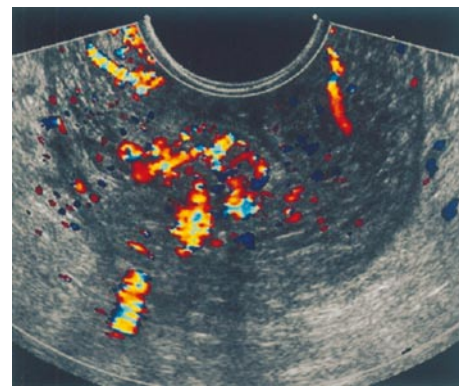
Trans-rectal Doppler sonography of colonic varices.
